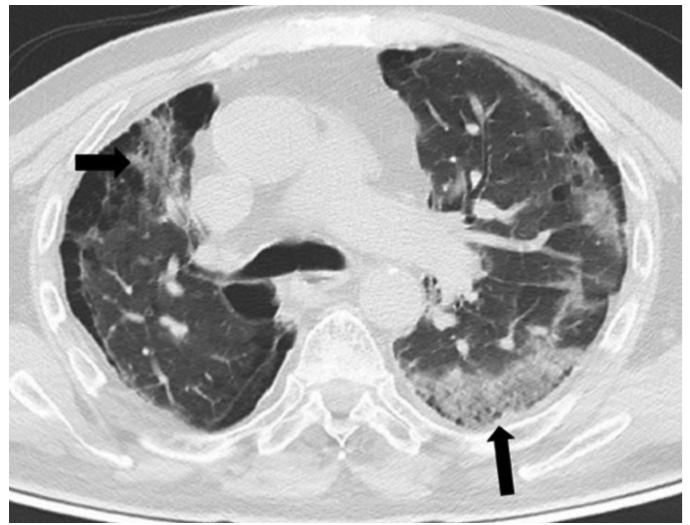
Thorax computed tomography shows peripheral and diffusely located ground glass opacities (black arrows) in both lungs
